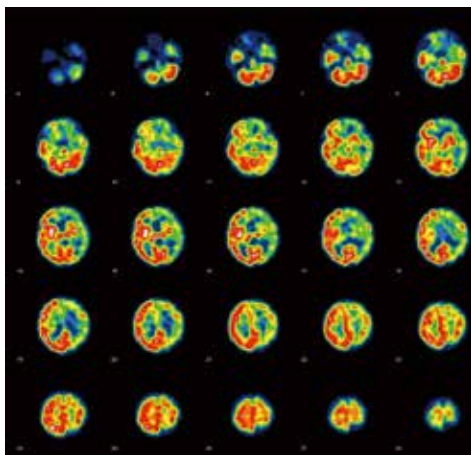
Inter-ictal brain SPECT (transaxial slices) showed a left hemisphere decreased cerebral blood flow.
